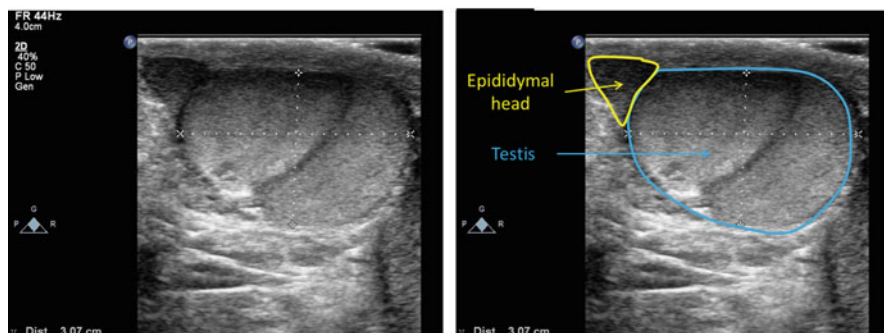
Ultrasound of testis showing head of the epididymis. Sperm are produced in the seminiferous tubules of the testes and are stored in the epididymis
